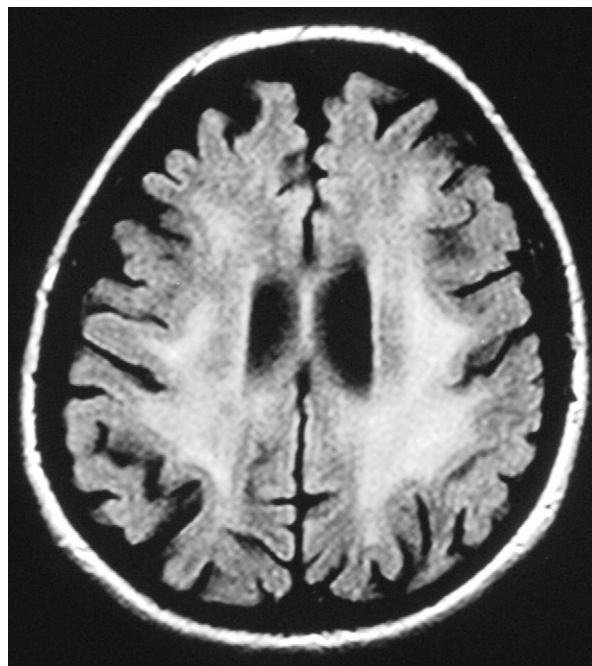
Axial, FLAIR image demonstrates diffuse, ill-defined hyperintense areas in the periventricular white matter, without significant mass effect.
